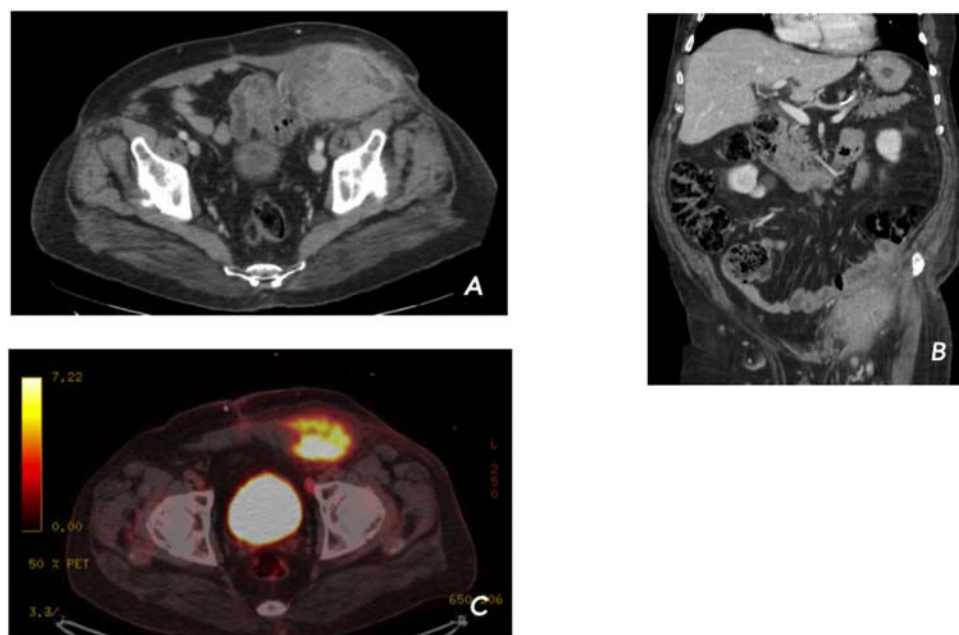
CT scan images (A, B) and PET/CT images (C), as described above.
